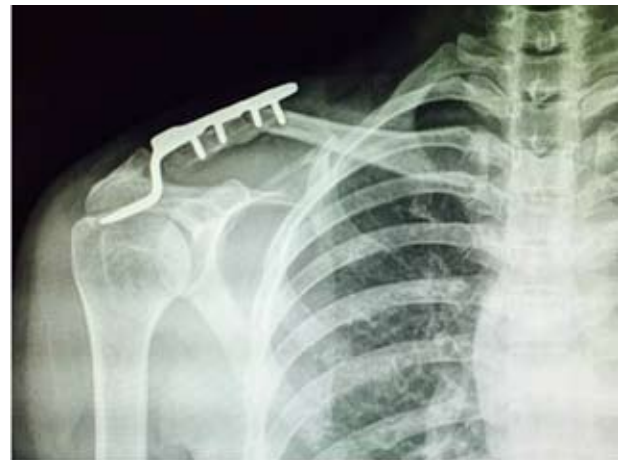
A radiograph revealing the clavicle fracture at medial end of the hook plate after injury.
